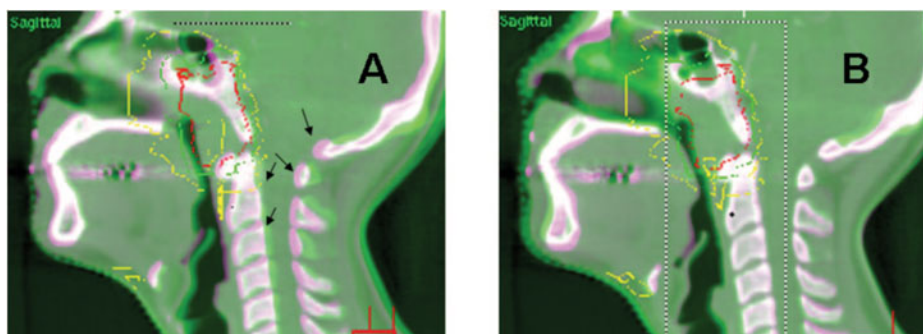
Three-dimensional (3D) image-guided radiation therapy (IGRT). A) Overlay of planning CT scan (reference scan) and 3D image acquired using a cone-beam CT scan (IGRT scan) at the treatment unit. Only a representative sagittal plane is shown. Double image (highlighted by arrows) is seen between the reference scan and the IGRT scan due to set-up errors (displacements) that were detected prior to treatment. It is important to note that axial and coronal planes are also captured of a 3D image and displacement corrections are made in 3D. B) Double image is not apparent as the displacements were corrected for prior to treatment by applying treatment couch shifts to offset displacements. Note that the rectangle defines a region of interest (ROI) for image-guided analyses of displacements and corrections.
